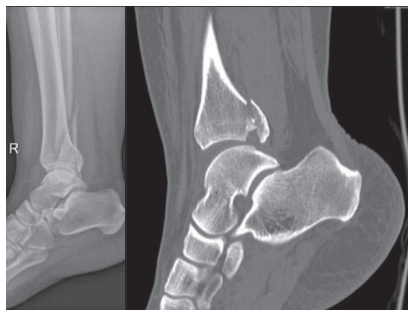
This patient with a trimalleolar fracture was initially not planned to have operative treatment of the posterior malleolar fracture. The CT-scan shows 2 large intra-articular fragment which will disturb anatomic restoration of the tibio-talar joint and increase the change of development of osteoarthritis.
